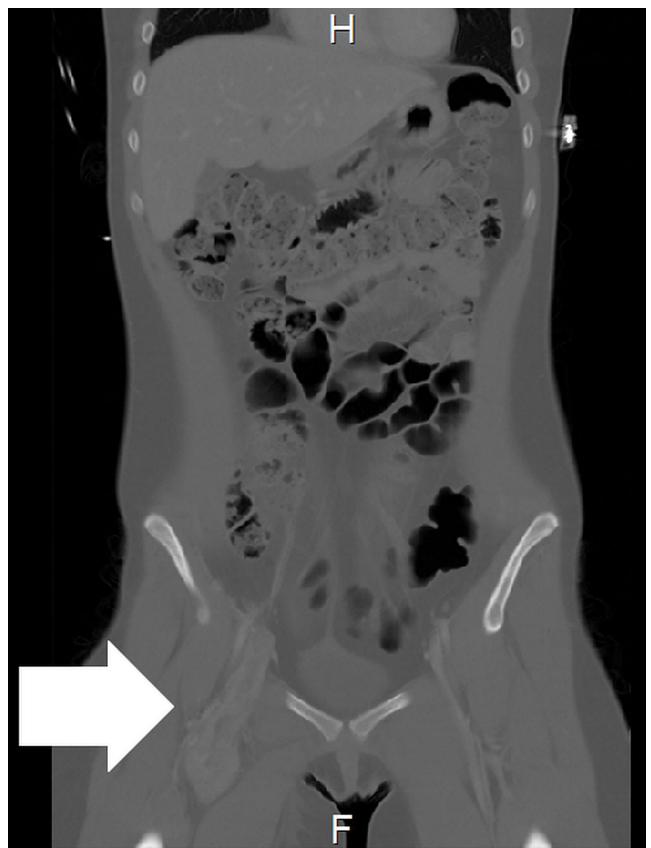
Computed tomography image, coronal view, shows a neoplastic mass (arrow) growing inside the right femoral and iliac vein.
